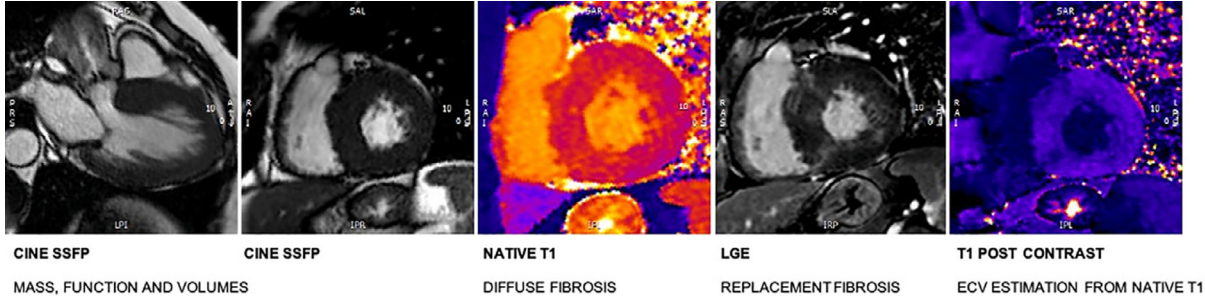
Example of a comprehensive cardiac MRI study focusing LV hypertrophy and remodeling in patients with aortic valve stenosis.
